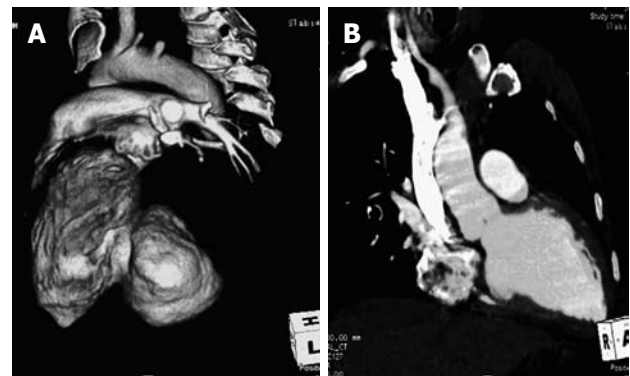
Computed tomography image of the heart. A: Volume-rendered image shows a large pseudoaneurysm arising from the postero-lateral wall of the left ventricle; B: Postoperative reconstructed oblique coronal image shows opacified left ventricular cavity without a pseudoaneurysm.
